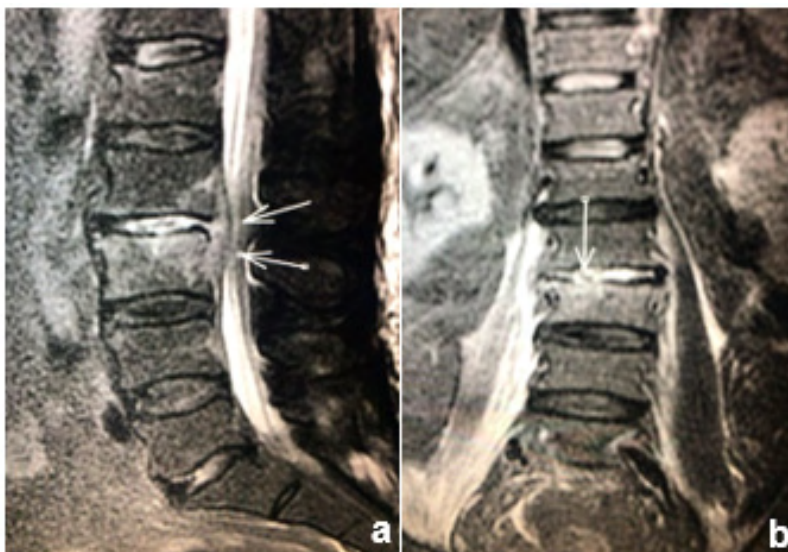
MRI of the lumbar spine. In a) sagittal T2, in b) coronal T2 showing expansive lesion.
